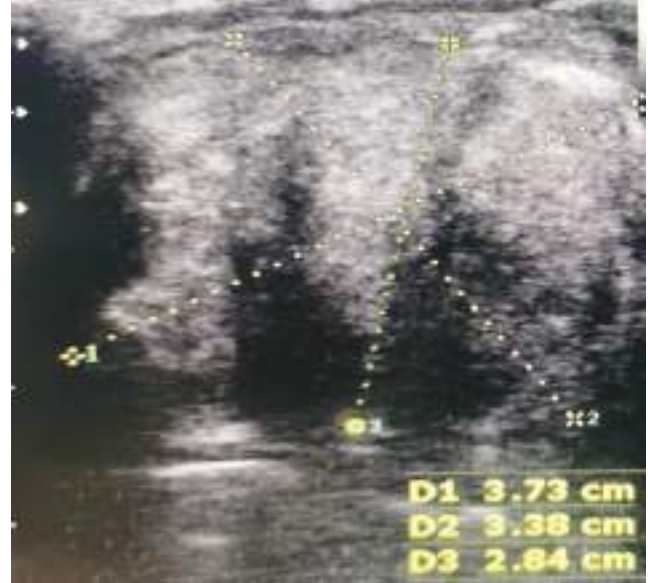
a) High resolution ultrasound image of neck showing two hyperechoic cauliflower like solid masses on the hyoid bone measuring about 3 cm X 2.2 cm and 1.5 cm X 1.4 cm. b) Normal sized thyroid lobes with uniform tissue echopattern are visible in the same patient.
